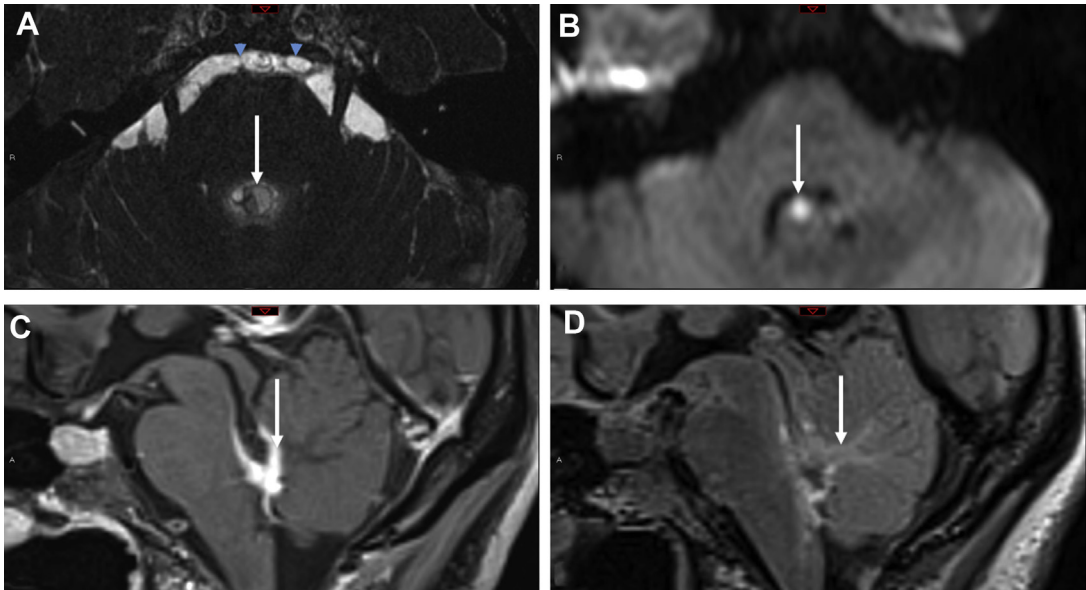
Neurocysticercosis. Axial heavily T2-weighted (A), axial diffusion-weighted (B), sagittal T1-weighted post-contrast (C), and sagittal FLAIR (D) MR imaging in a 30-year-old patient with headache. The scolex is identifiable as a cystic intraventricular focus with corresponding diffusion restriction (*white arrows* in A and B). Inflammatory ependymal enhancement (*white arrow* in C) and periventricular edema (*white arrow* D) contribute to obstruction of the fourth ventricular outflow foramina and hydrocephalus (not shown). Additional racemose disease is appreciable in the prepontine cistern on heavily T2-weighted images (*blue arrowheads* in A).
